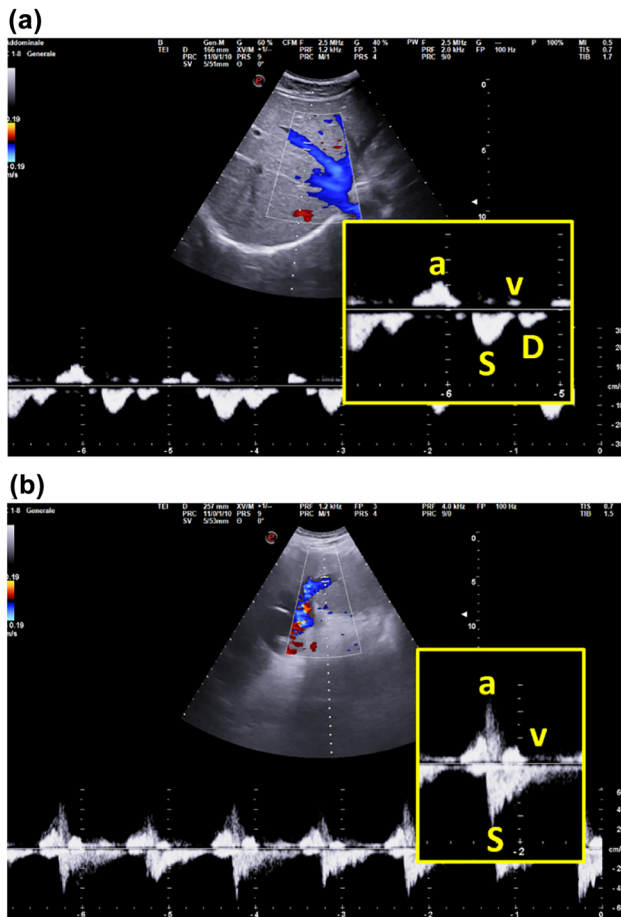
Spectral Doppler pattern of IV: normal triphasic wave in suprahepatic veins (a); a-S-v complex in patient with HF and severe volume overload (b).
